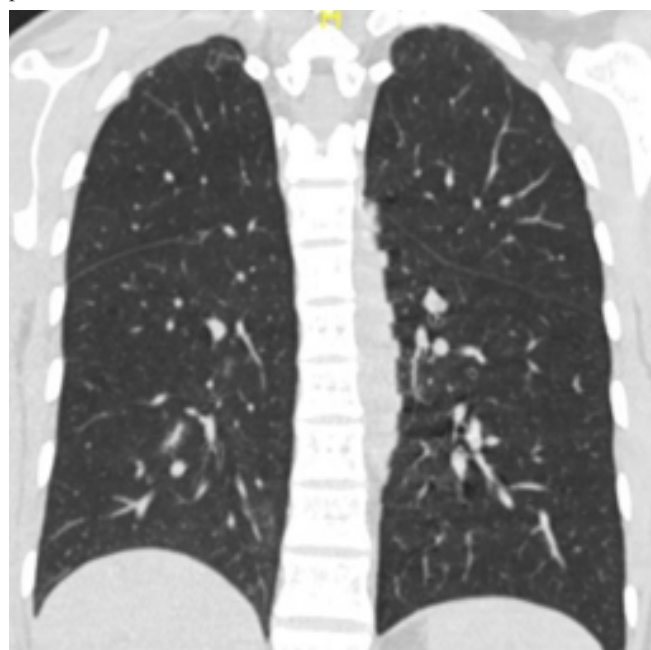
Thoracic CT coronal section image taken after the treatment of first attack.
